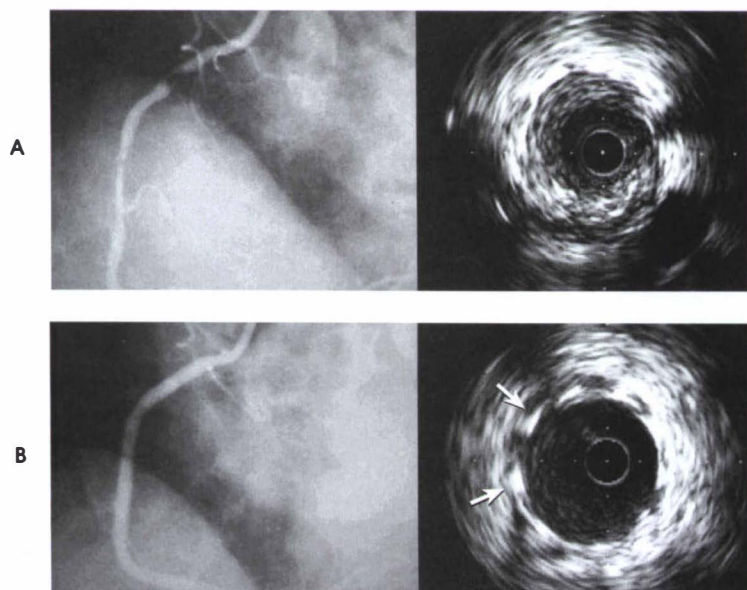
Intravascular ultrasound images shown on right correlated with angiography images on left. Arrows in B shows the echogenicity of the stent struts during IVUS.
